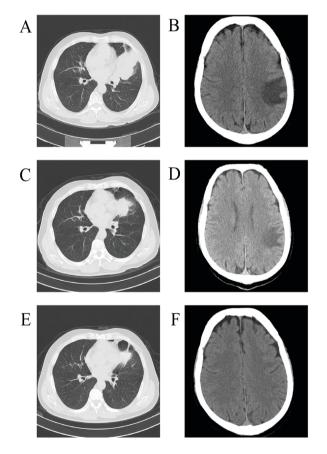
Computer tomography (CT) scans of lung lesion and brain metastasis before and after icotinib treatment. (A and B) At diagnosis of the metastases (Oct 12, 2013); (C and D) After 16 days of icotinib therapy (Oct 28, 2013), revealing a good response to treatment; (E and F) After 47 days of icotinib treatment (Nov 26, 2013), revealing brain lesion completed resolved.
